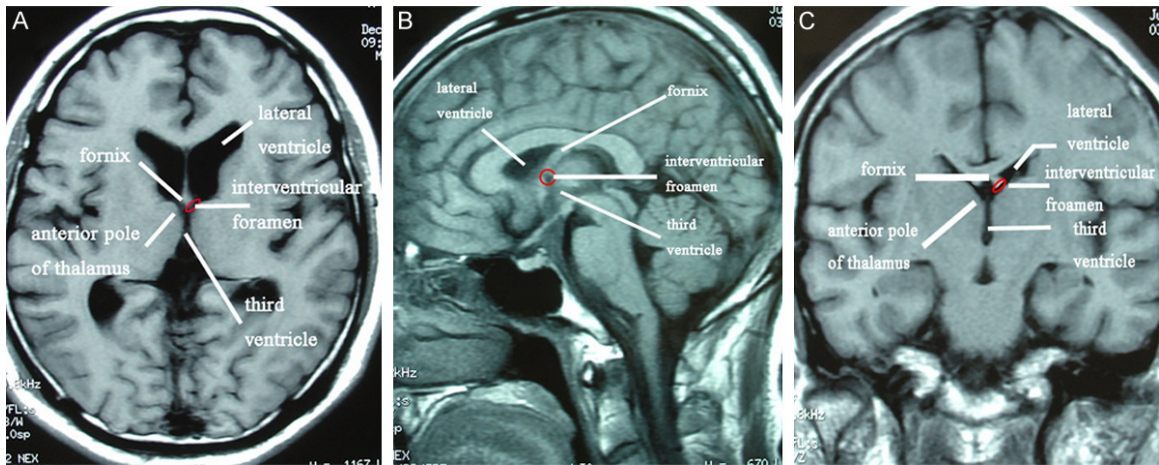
The normal interventricular foramen on MRI. A-C.
